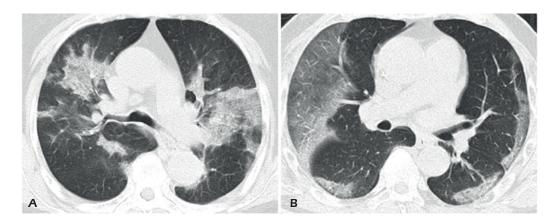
Chest CT images of "butterfly sign" or "upside-down butterfly sign" for typical severe-stage COVID-19. A, A chest CT image of an 80-year-old female COVID-19 patient. Chest CT re-examination shows that the two hilums are symmetrically distributed with large clumps of or fusion-like consolidation, showing "butterfly sign". B, A chest CT image of a 57-year-old male COVID-19 patient. Chest CT shows that GGO was distributed symmetrically and extensively under the pleura on both lateral sides of the lungs, with the long axis parallel to the pleura showing an "upside-down butterfly sign".
